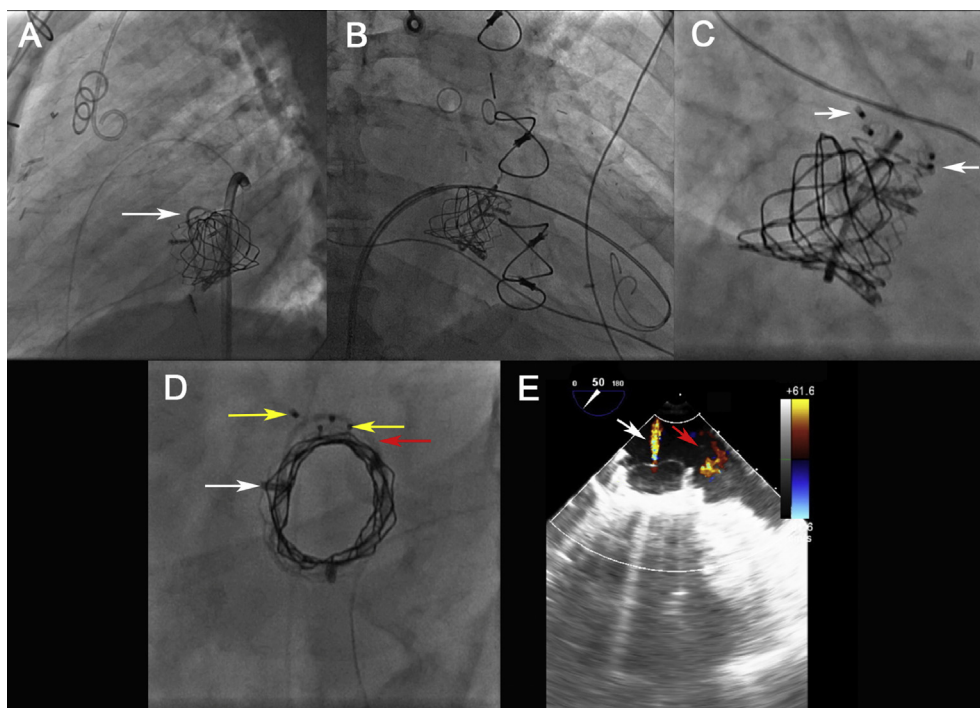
Paravalvular leak (PVL) closure. A) Fluoroscopy revealed PVL space between percutaneous valve and surgical mitral ring (arrow). B) PVL space was cannulated with a wire and C) closed with a 6 mm and an 8 mm Amplatzer Vascular Plugs II (arrows). D) Final fluoroscopy revealed percutaneous valves (white arrow) with the residual PVL space between the valve and the oval mitral ring (red arrow), which was closed by the two vascular plugs (yellow arrows). E) Final transesophageal echocardiogram (TEE) revealed minimal central MR (white arrow) and mild residual paravalvular leak (red arrow).
